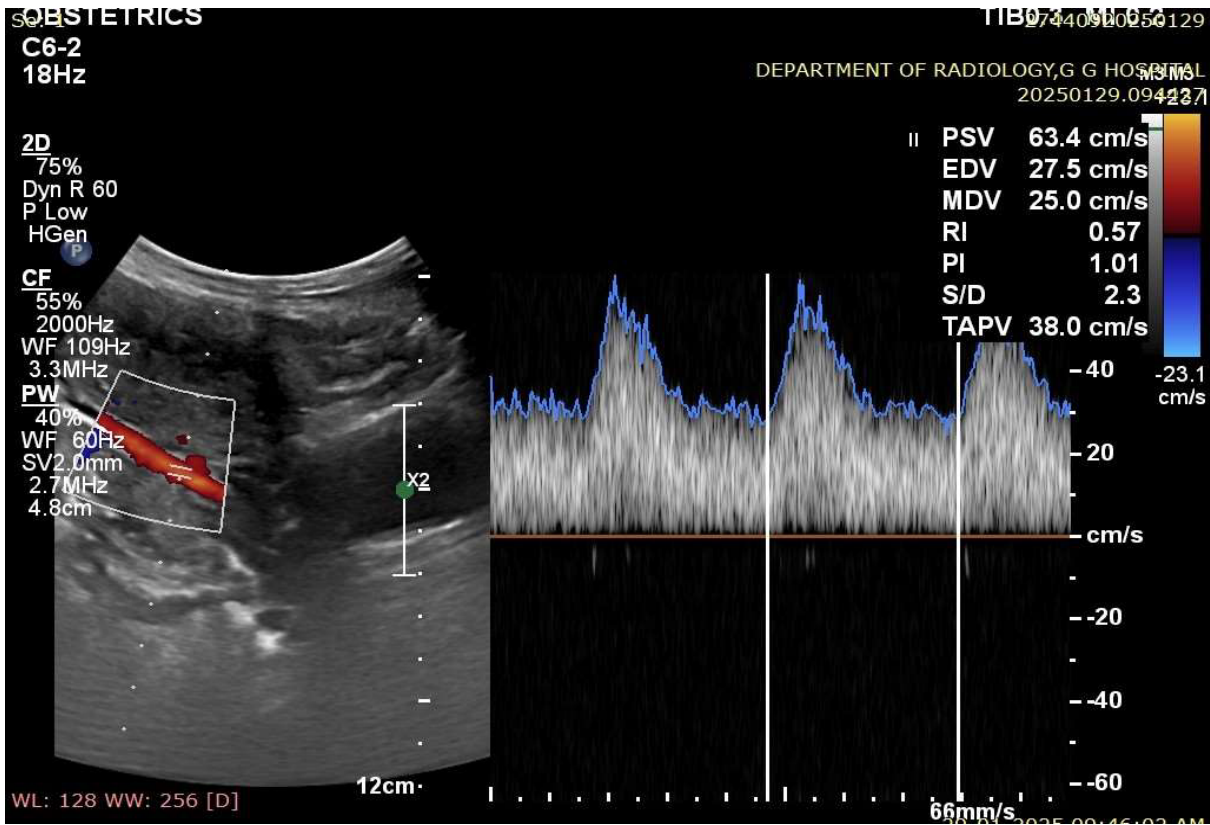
Normal uterine artery Doppler with normal RI and PI and no proto-diastolic notch
